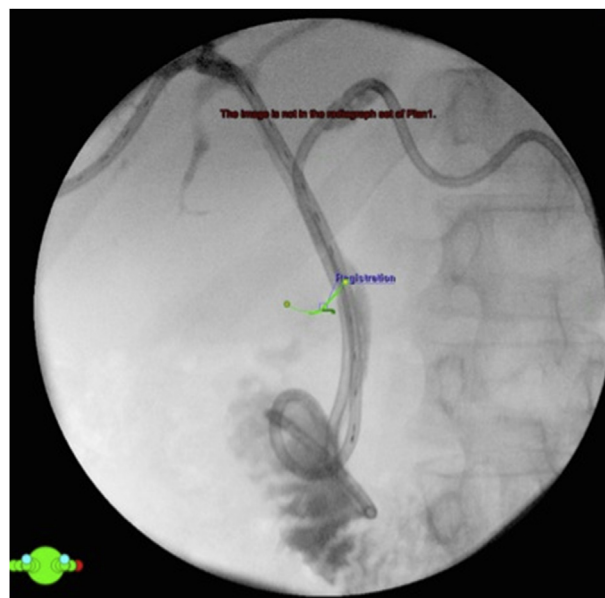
X-ray images confirming the position of the marker-wire with a centimeter scale. The wire was inserted into the percutaneous biliary drains to aid in the marking the position of the tumour and length of the intraluminal brachytherapy radiation field.
